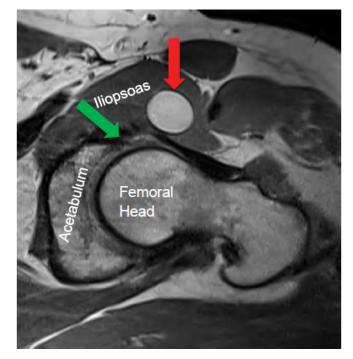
MRI Left Hip (Axial View): This demonstrates the left hip anterior paralabral cyst (red arrow) with associated anterior labral tear (green arrow).
